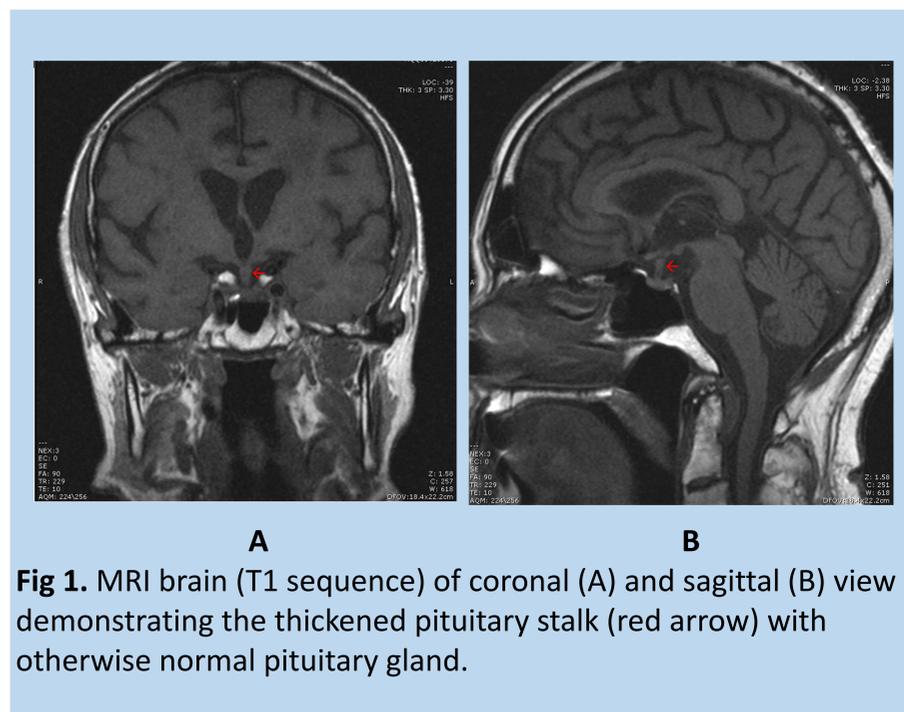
MRI brain (T1 sequence) of coronal (A) and sagittal (B) view demonstrating the thickened pituitary stalk (red arrow) with otherwise normal pituitary gland.
